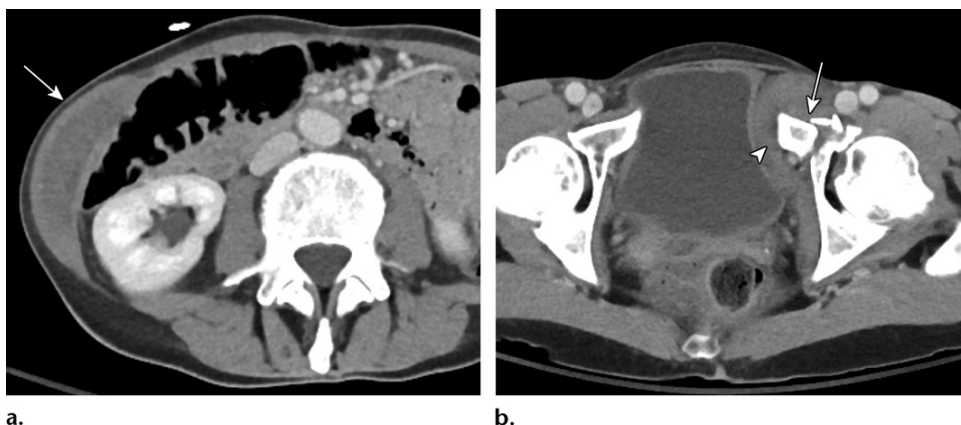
MLL with associated pelvic fractures in a 62-year-old female pedestrian who was struck by a bus. (a) Axial CT image shows a low-attenuation area of expansion (arrow) within the lateral abdominal wall musculature, a finding consistent with an MLL. No active hemorrhage is depicted. (b) Axial CT image obtained more inferiorly than (a) shows a left superior pubic ramus fracture (arrow), with an associated pelvic sidewall hematoma (arrowhead).
